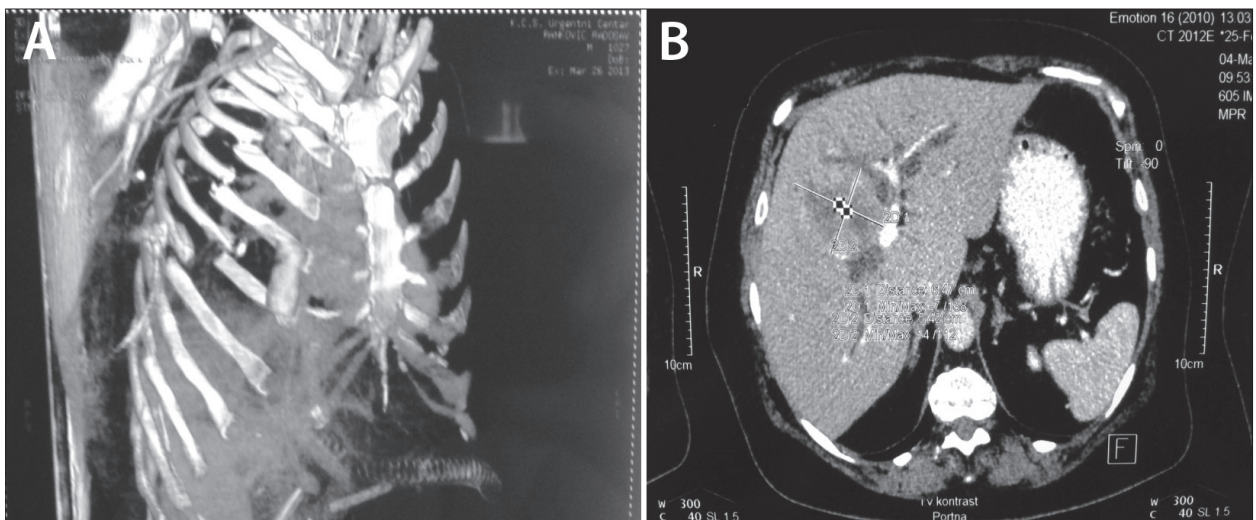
CT findings of severe thoracoabdominal trauma with serial rib fractures (A) and liver injury (B)
